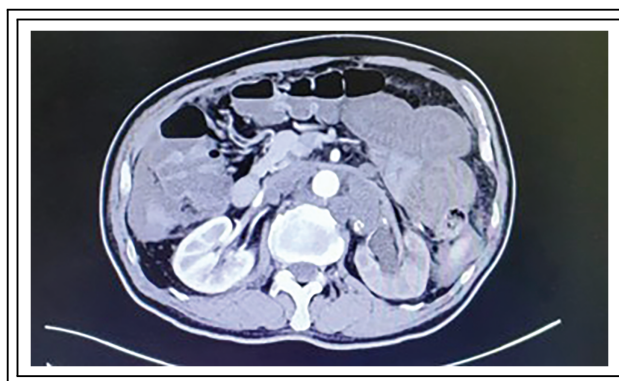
Computed tomography (CT) indicated mild hydronephrosis eighteen months after the stent removal
